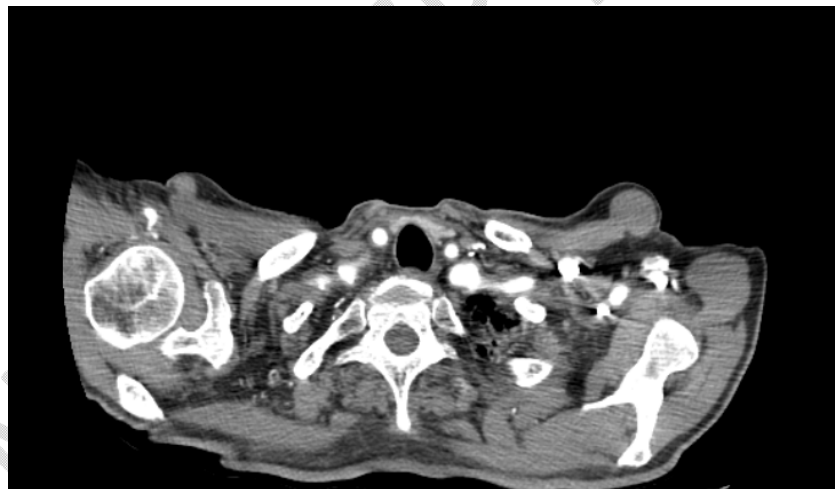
Transverse thoracic high CT scan showing circumferential wall thickening of the common carotids, more pronounced on the right side.
